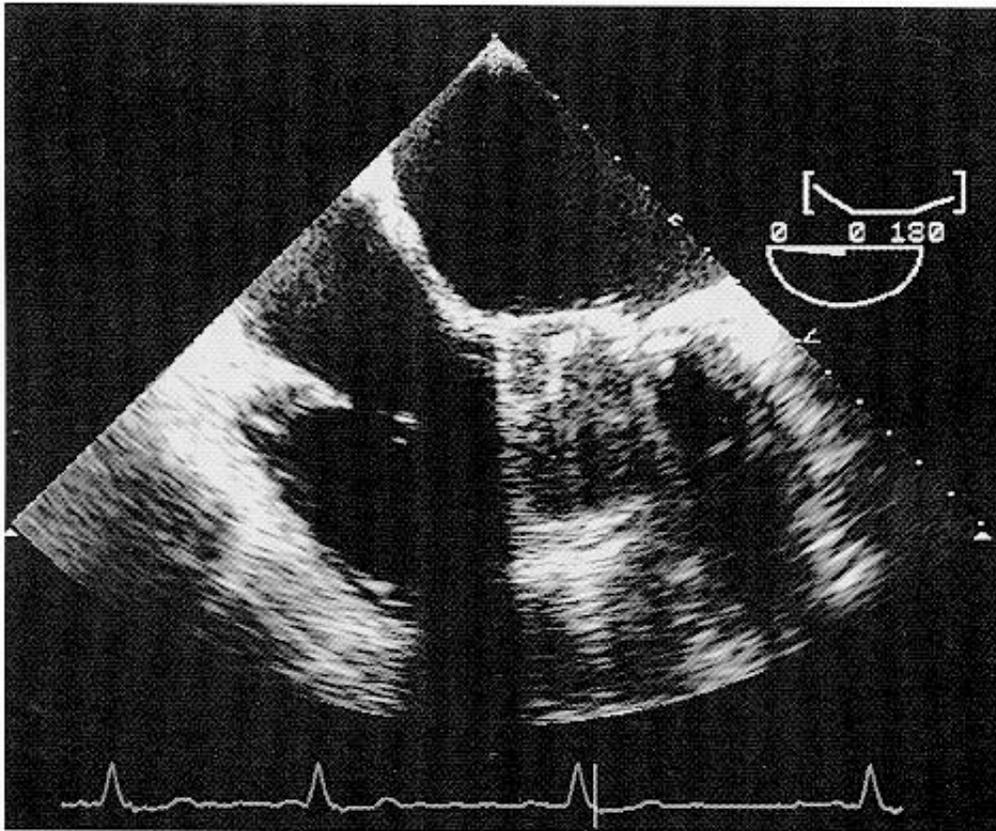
Ultrasound-imaging artifacts associated with mechanical prosthesis in mitral position. Reverberation artifacts appear as redundant echoes distal to prosthesis. Mirror-image artifact appears as second iteration of prosthesis displayed at twice the distance from the transducer. Acoustic shadowing results from loss of ultrasound penetration beyond prosthesis.
